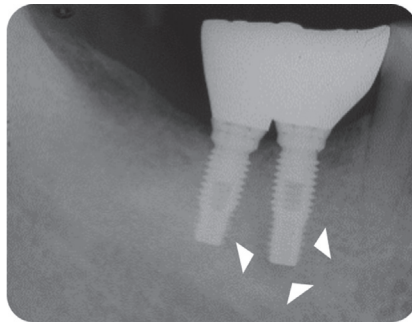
The periapical radiolucency still existed at the time of the placement of implant prosthesis. Arrow heads depict the extent of IPL.
